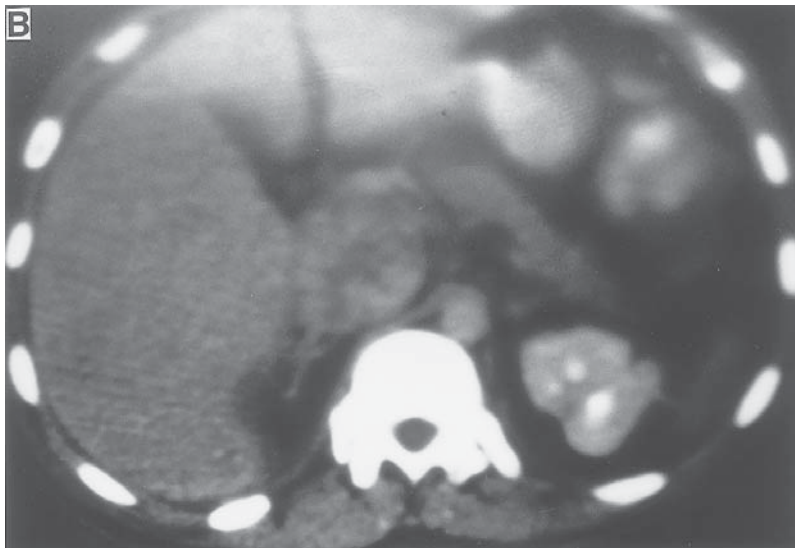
(A) Antegrade venacavogram showing total cava occlusion. (B) CT scan in same patient with filling of IVC by tumor.
